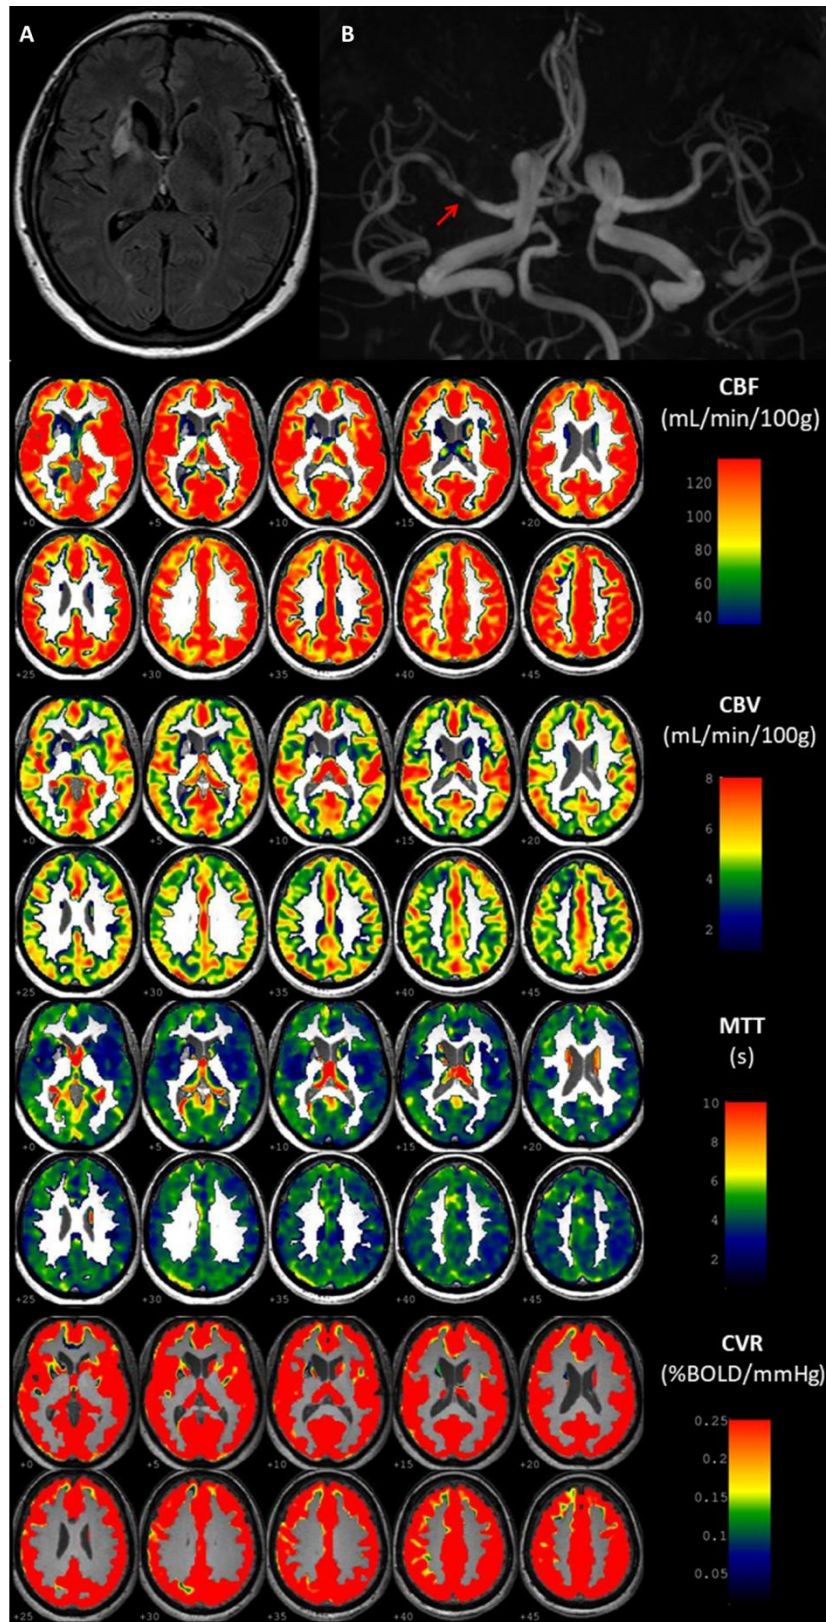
FLAIR-T₂ weighted image (A), Time-Of-Flight weighted image (B), basal perfusion parameters and CVR maps in 68-year woman referred for symptomatic right MCA stenosis in red arrow, without ischemic recurrence (radiological convention).
